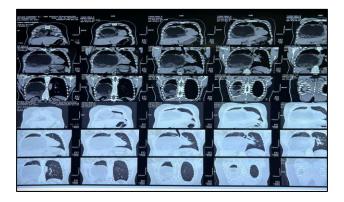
A coronal section chest CT scan showing a huge mature cystic teratoma occupying the right hemithorax.
